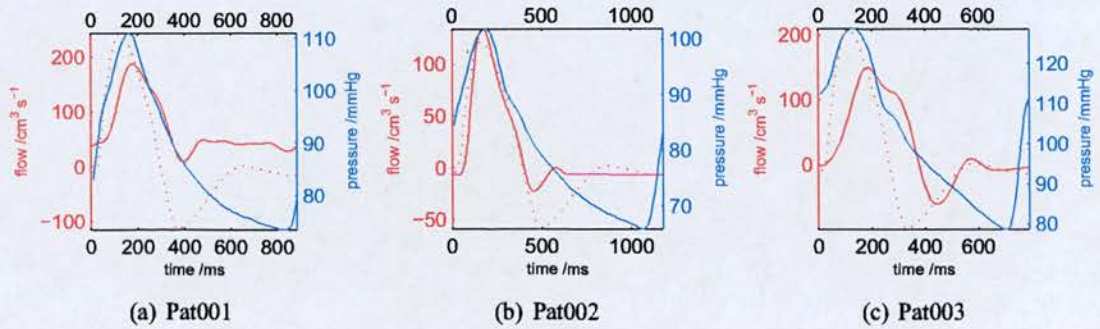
Inlet flow and outlet pressure. Solid red line is the flow wave from the MRI data. Dashed red line is the flow wave from the archetypal velocity wave.
